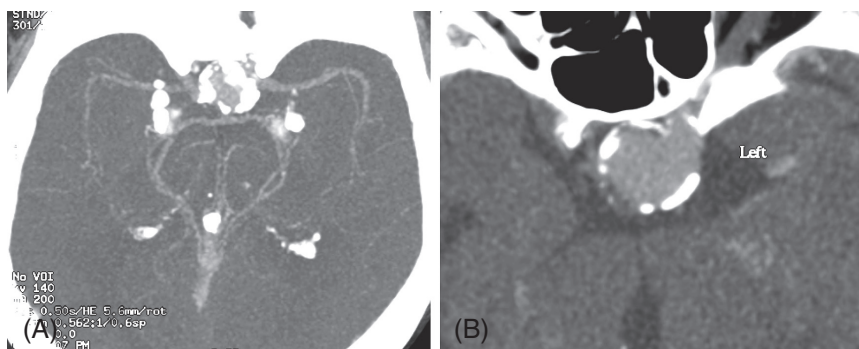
Gadolinium CTA performed in a patient with severe iodinated contrast allergy: Despite suboptimal vascular opacification relative to iodinated contrast (A), the diagnosis of a 1.9 cm left PCOM aneurysm is still clear (B).
